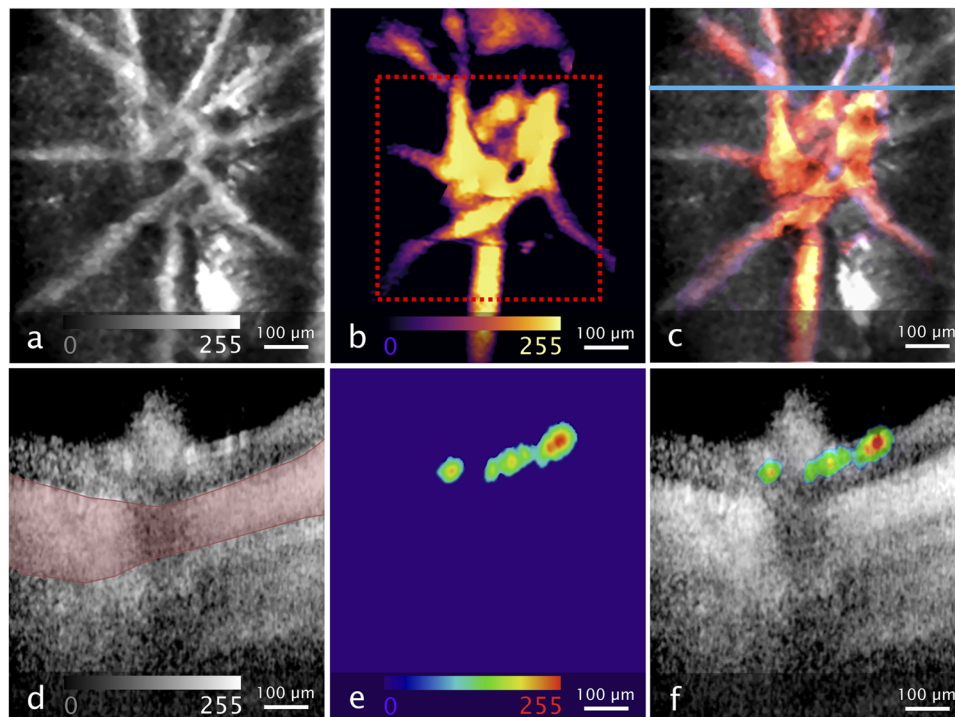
Multimodal OC-PAOM imaging results. (a) An en face average intensity OCT projection of the nerve head region. (b) An en face maximum intensity PAOM projection of the same region. Dotted red square: active area of the ultrasound transducer. (c) Multimodal OC-PAOM en face projections, with PAOM in color. (d)–(f) OCT, PAOM, and OC-PAOM B-scans at the indicated position in (c) (blue line). Red shaded area: choroid. OCT and PAOM en face projections in (a)–(c) are generated at the depth of the retinal vasculature and after 3D median filtering of the acquired volume. The scale bar is valid for all spatial directions.
